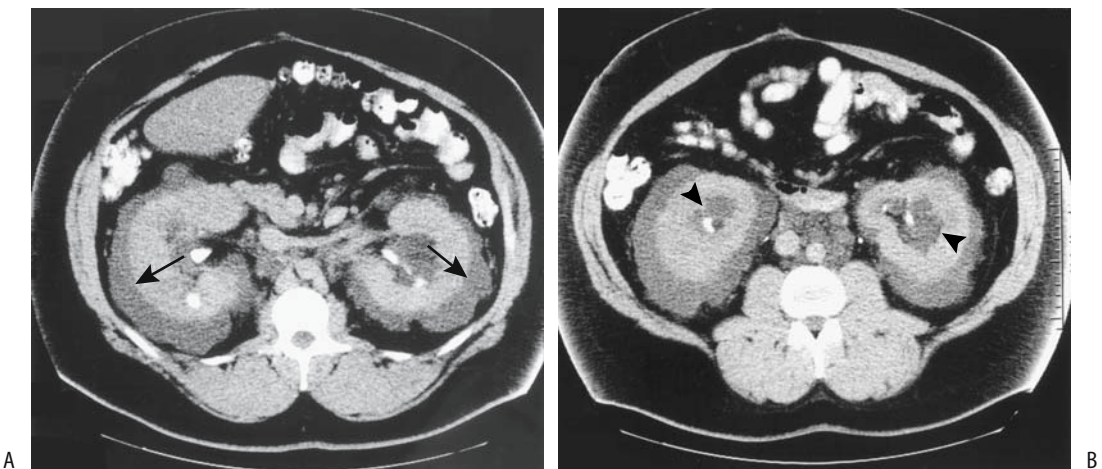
Renal lymphangiectasia. A,B: Transverse contrast-enhanced CT images show bilateral perirenal fluid (arrows), peripelvic fluid (arrowheads), and fluid around great vessels. Attenuation of the perinephric collections is less than 10 HU (Source: Ramseyer LT. Case 34: renal lymphangiectasia. *Radiology* 2001;219:442–444, with permission from the Radiological Society of North America.)
